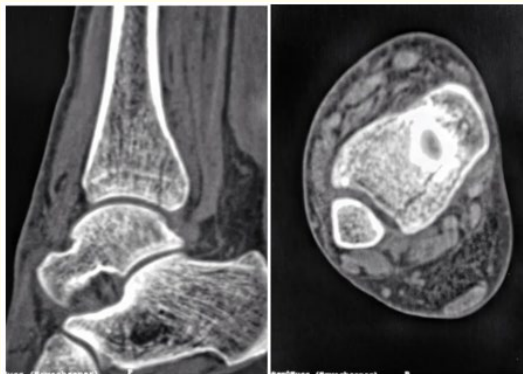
CT scan showing fracture extension into the dorsal tibial plafond.
